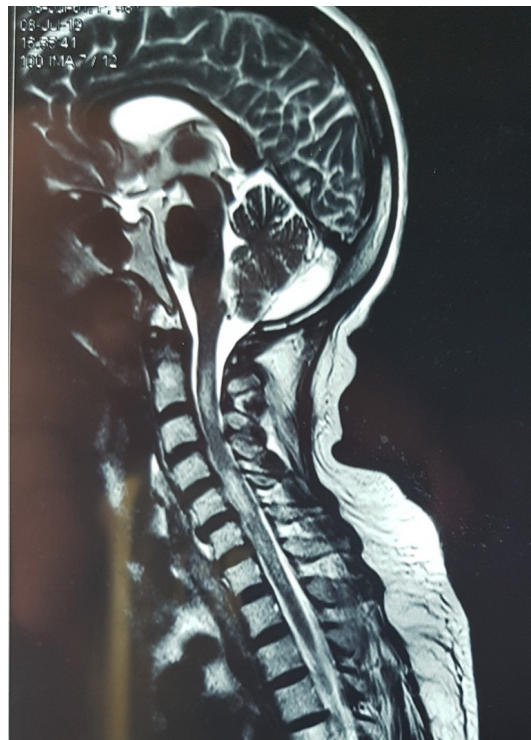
MRI brain showing hyperintensity in the cervical cord.
